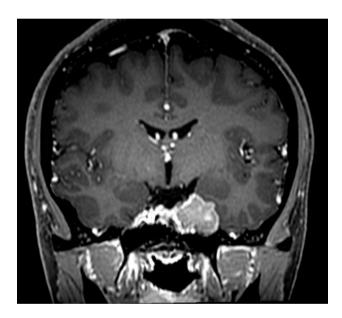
Four months after the surgery, brain MRI revealed the tumor size had decreased from $40 \times 20 \times 19$ mm to $23 \times 19 \times 19$ mm
